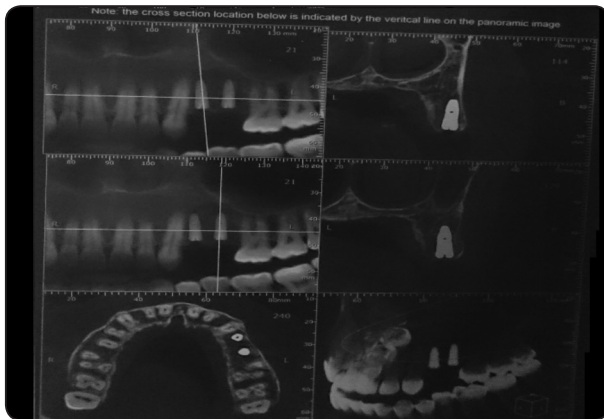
postoperative CBCT
